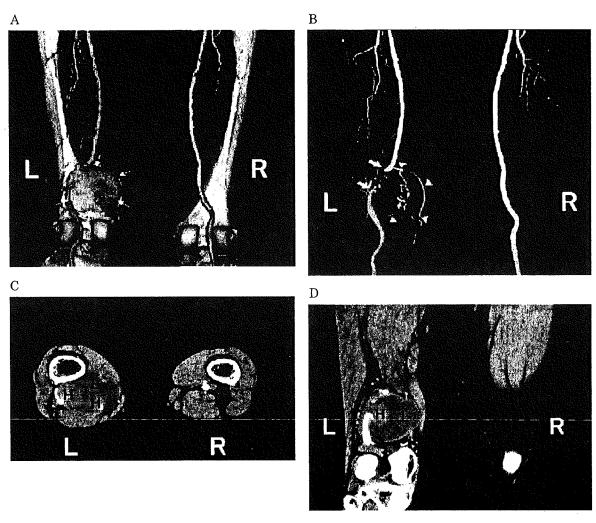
Three-dimensional reconstruction image of an enhanced computed tomographic scan of lower limbs revealed huge 65×70×50-mm mass above the left knee joint (A; thin white arrow). Computed tomographic angiogram showed an obstruction of the left popliteal artery just behind the mass (B; thick white arrow). Abundant collateral arteries were observed running around the mass and connecting into the distal part of popliteal artery (B; arrowheads). A horizontal section (C) and oblique vertical section (D) of the mass revealed 2 internal high-density enhanced areas (H) surrounded by an outer low-density area (L) with capsule.
